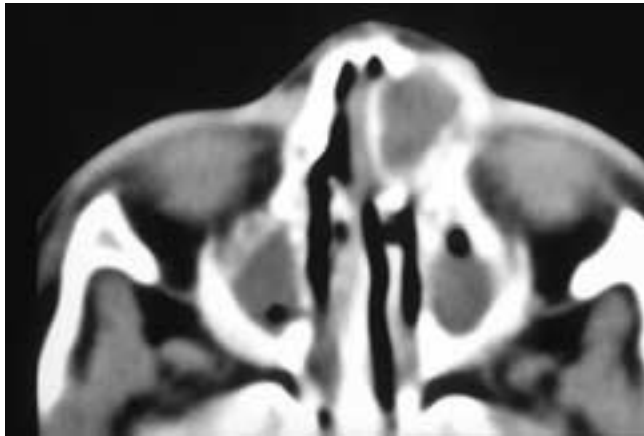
Axial CT scan shows a soft-tissue mass in the left lacrimal duct region bulging into the left nasal fossa. The bone has been remodeled around the lesion. Incidentally noted are inflammatory secretions in both maxillary sinuses. This patient had a low-grade fibrosarcoma.
